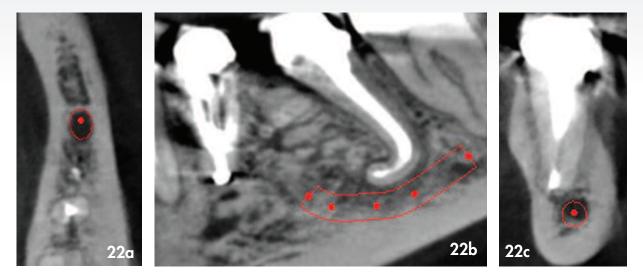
(a) Axial view, (b) sagittal view and (c) coronal view of a post-operative CBCT scan that confirmed healing of the periapical pathology at the one year recall visit.
